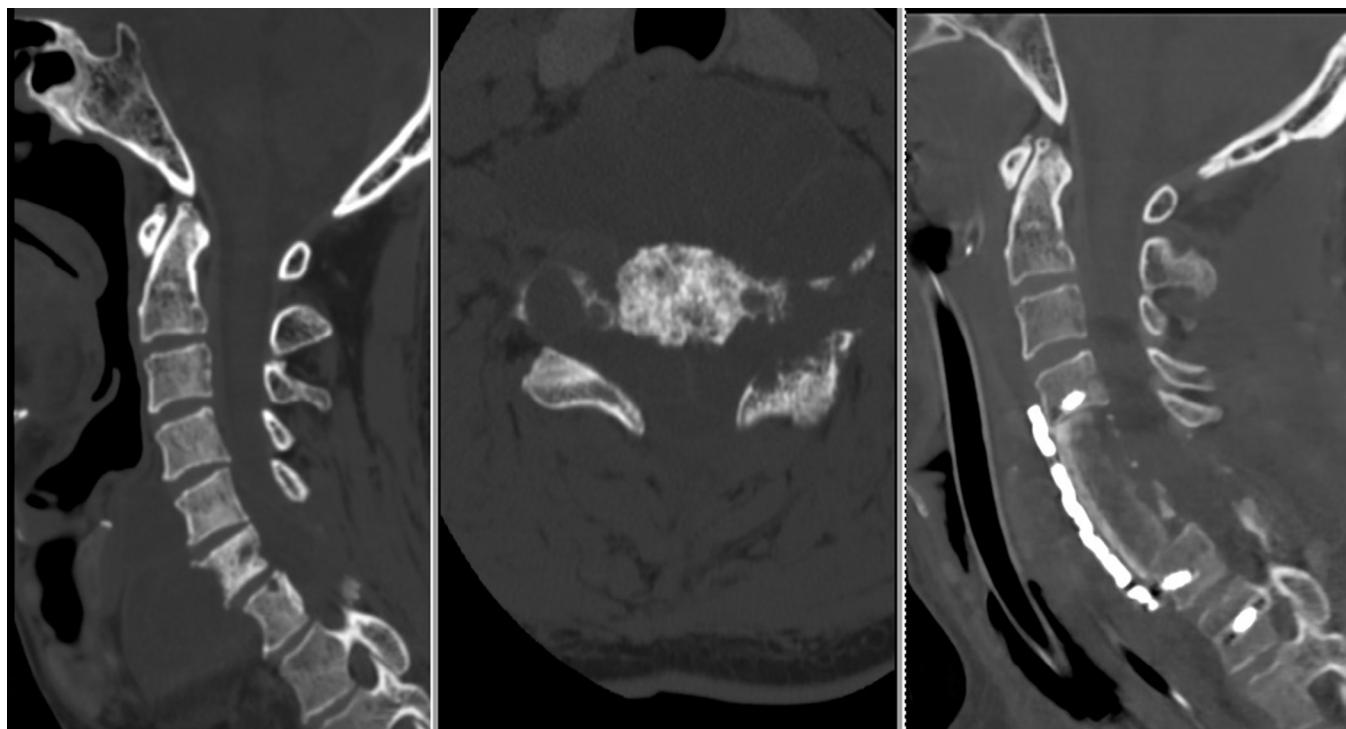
CT of the cervical spine showing (Left) lytic changes in the C6 body and C6, C7 laminectomy defect; (Middle) multi-columnar involvement and bilateral foraminal widening. (Right) Postoperative CT showing an iliac bone graft in the C5, C6 corpectomy defect and a plate from C4 to C7.
